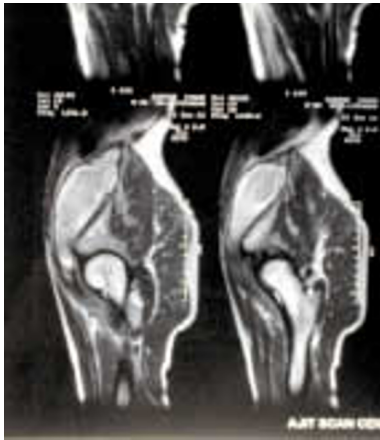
MRI of Hip Joint showing presence of haematoma in the left iliac fossa extending up to iliopsoas insertion in the lesser trochanter.
